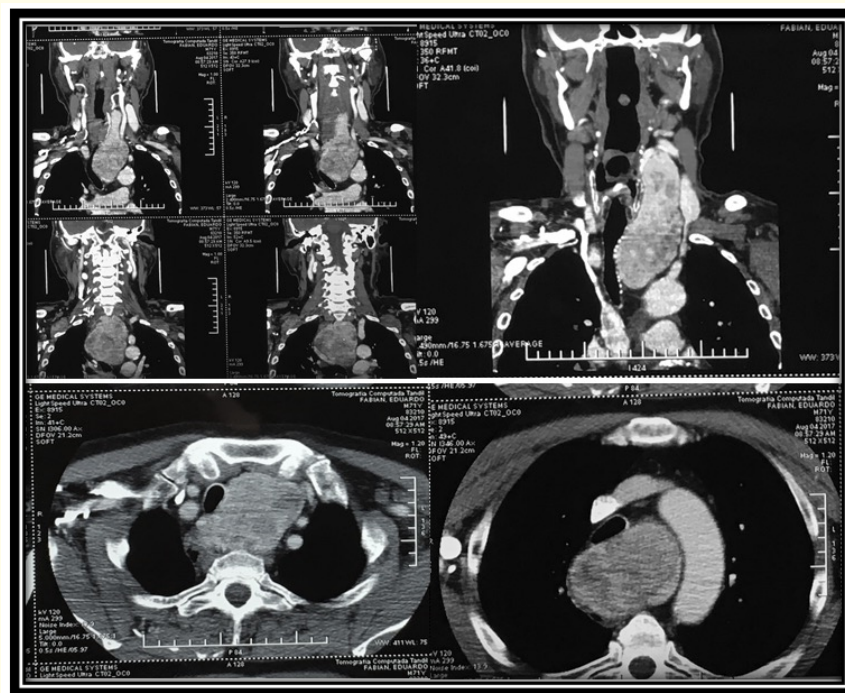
CT scan coronal slices. Huge cervical mass with intrathoracic extension, partially collapsing de trachea(*) with antero-posterior disposition.
